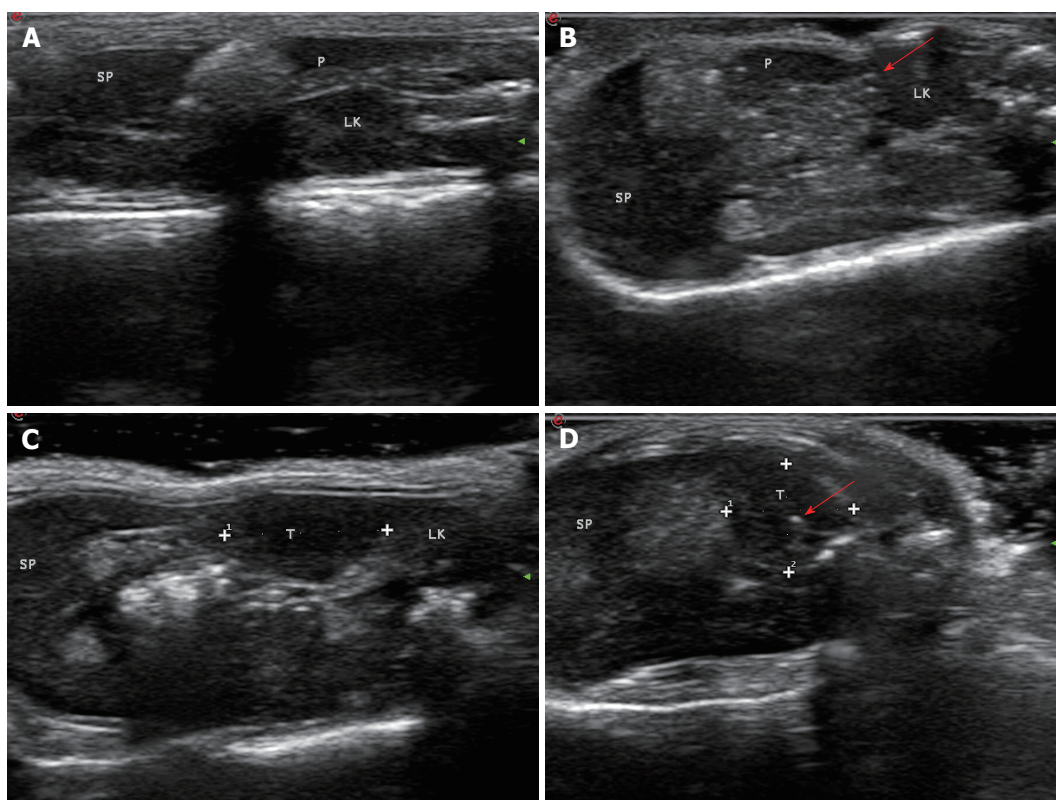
Evaluation of therapeutic effects of irreversible electroporation on tumors *in vivo* by ultrasound. A: A pre-irreversible electroporation ultrasound image showing the normal pancreatic parenchyma; B: The ablation zone showed hyperechoic signals with a comet tail sign in the normal pancreatic tissue (arrow); C: White dots indicate the region of the tumor; D: Ultrasound image showing that the irreversible electroporation ablation zone in the tumor tissue became hyperechoic (arrow). SP: Spleen; LK: Left kidney; P: Pancreas; T: Tumor.
